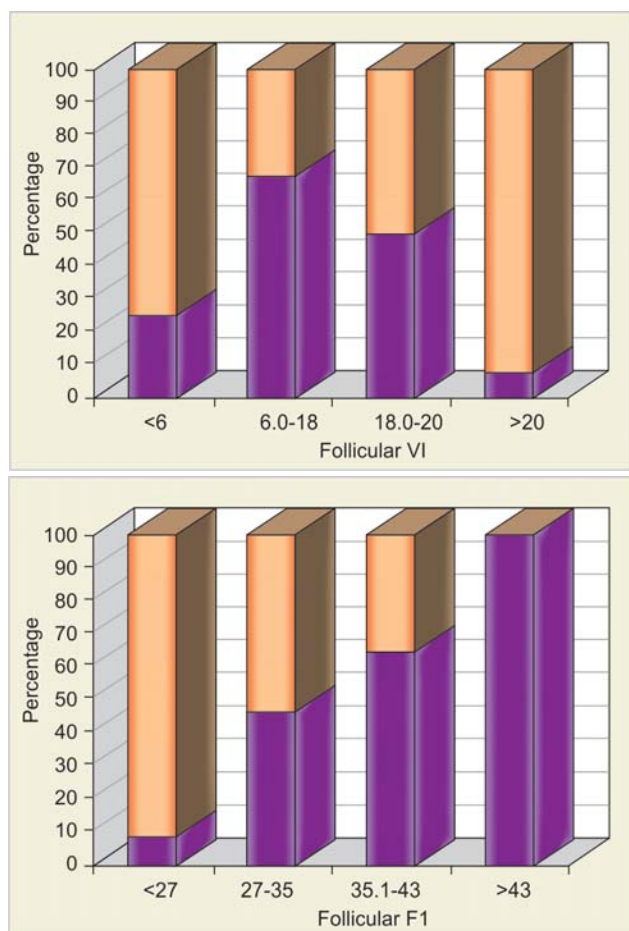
Pre-hCG perifollicular 3D power Doppler values
